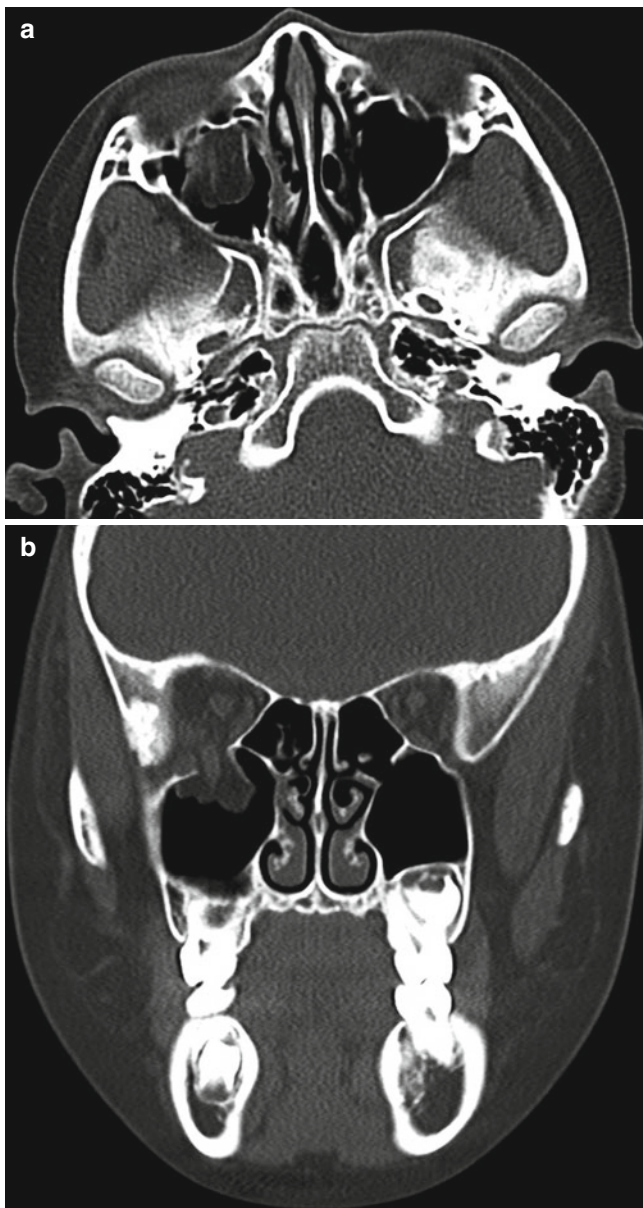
Inferior orbital blowout fracture. (a, b) Axial (a) and coronal (b) facial bone CT show a large defect in the right orbital floor with herniation of orbital fat into the right maxillary sinus. Right inferior rectus muscle is included in the herniated content
